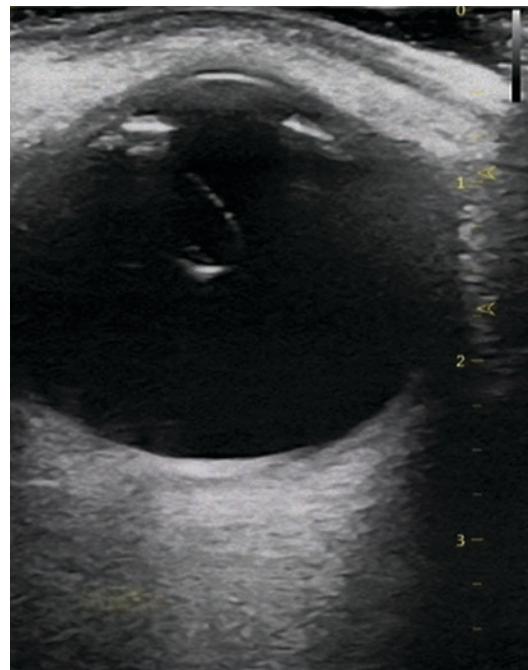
B-scan ultrasonography of the right eye showed the whole lens dropped into vitreous cavity vertically with a small portion of the zonular linked to the ciliary body
